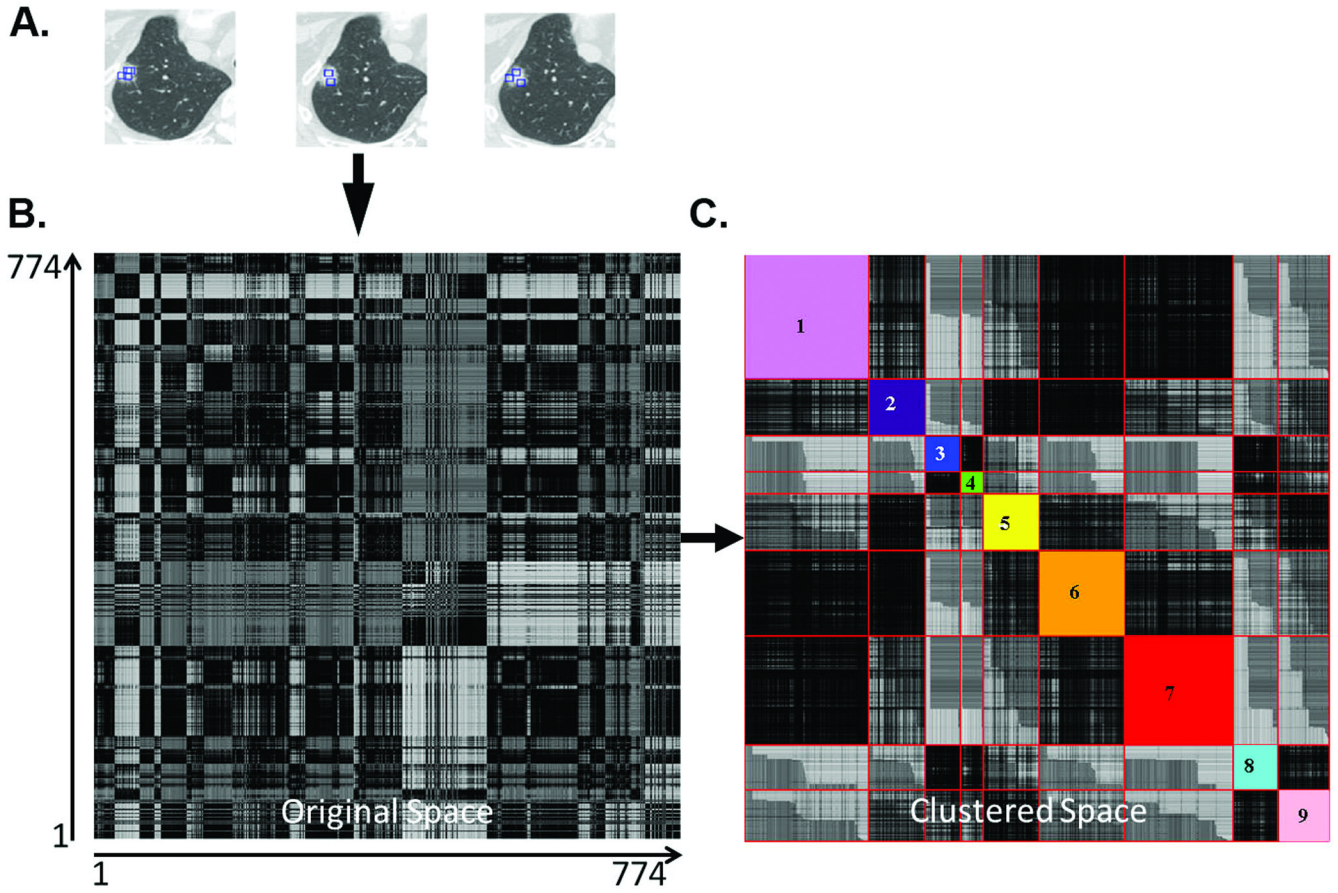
Natural clustering of HRCT regions of interest (ROI) of lung nodules. Panel A shows representative ROIs selected from different nodules in the training set. Each of the 774 ROI were compared with each other to derive the pairwise 774×774 similarity matrix and color coded (Panel B) such that the darkness is proportional to the similarity. Panel C shows the similarity matrix in the Affinity Propagation based clustered space wherein the arbitrarily color-coded diagonal sub-blocks show the automatically computed natural clusters.
